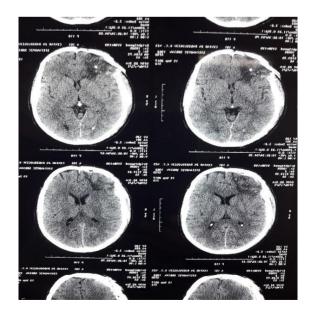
Control CT of the brain
